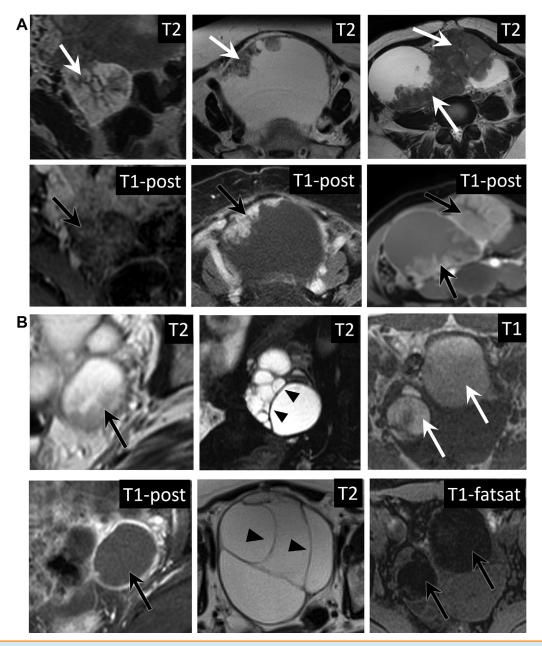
Solid tissue and nonsolid tissue. (A) Solid tissue conforms to one the following morphologies (white arrows) on T2-weighted imaging: papillary formation (left), mural nodules (middle), irregular cyst wall or septation, and solid portion (right). By definition, solid tissue enhances (black arrows) on T1-weighted imaging postcontrast. (B) Nonsolid tissue: debris that does not enhance on T1-weighted imaging postcontrast (black arrows, left), thin septations (arrowheads, middle) that may or may not enhance, and fat (white arrow, top right), which decreases in signal intensity on fat-saturated images (black arrow, bottom right).
